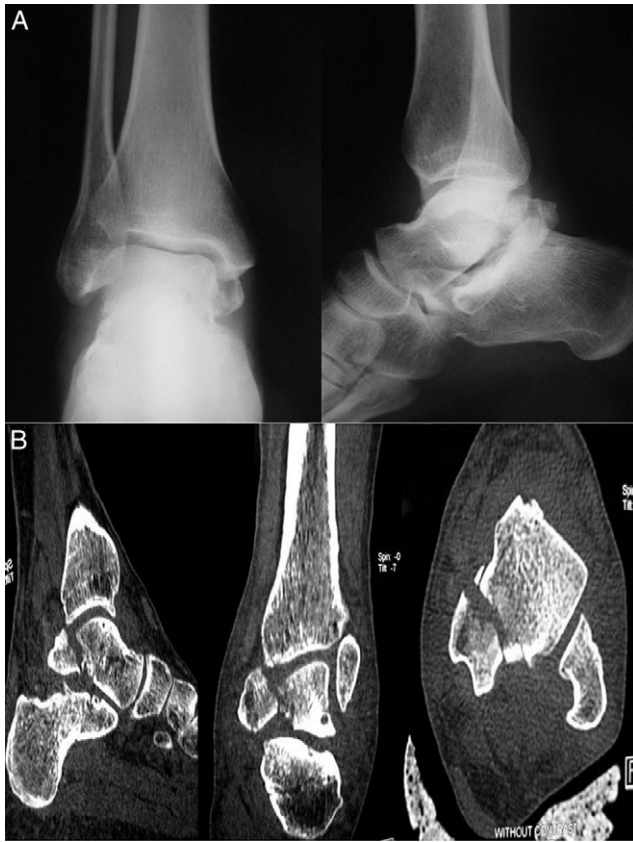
Anteroposterior and lateral views of preoperative standard radiographs (A) and CT scans (B) of the entire posterior talar process fracture in Case 1.
